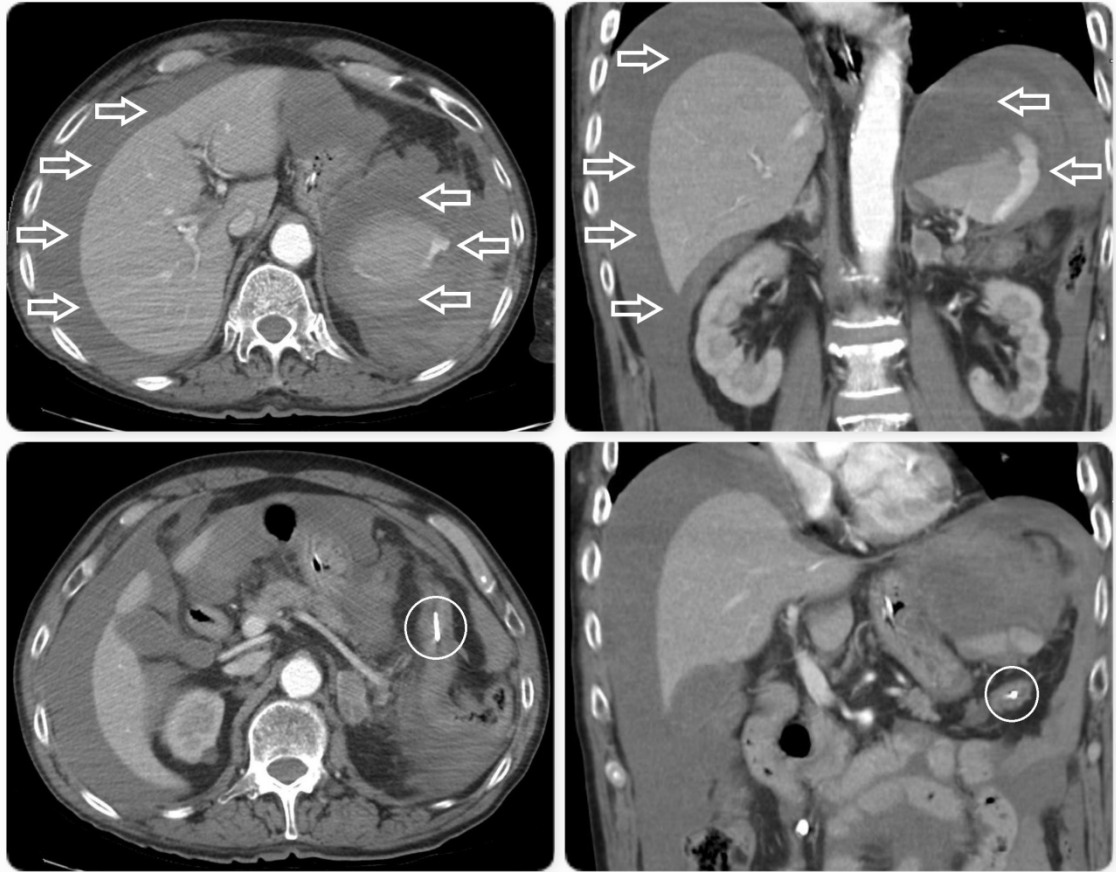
Urgent abdominal computed tomography. Left images: axial view; right: coronal view. Upper images: hemoperitoneum and splenic hematoma with active bleeding (white arrows). Lower: clip placed at splenic flexure of colon (white circles).
